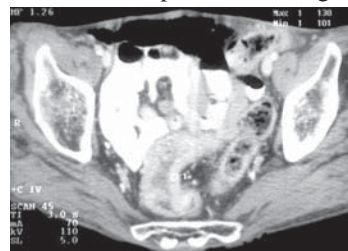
CT scan showing rectosigmoid carcinoma with mural thickening and intraluminal narrowing
